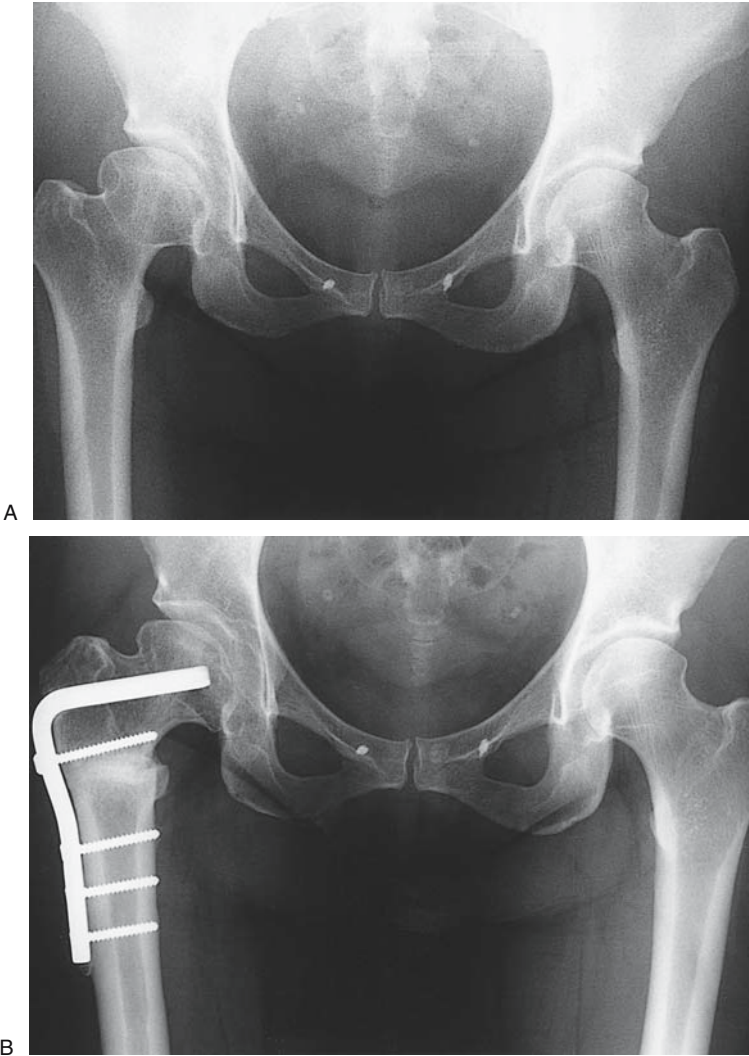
A 37-year-old woman with 1 year of increasing right hip pain. (A) Initial AP radiograph demonstrates a large femoral head with a shortened femoral neck, most likely the late result of Perthe's disease of the hip. (B) The patient underwent an osteotomy of the proximal femur to address her hip pain.
